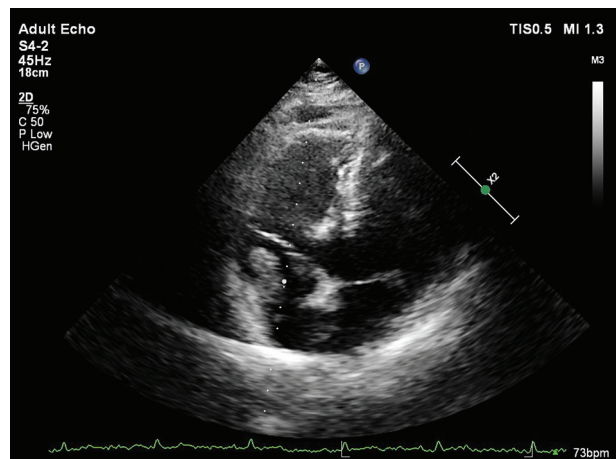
A transthoracic echocardiogram with formation attached to right atrial wall.
